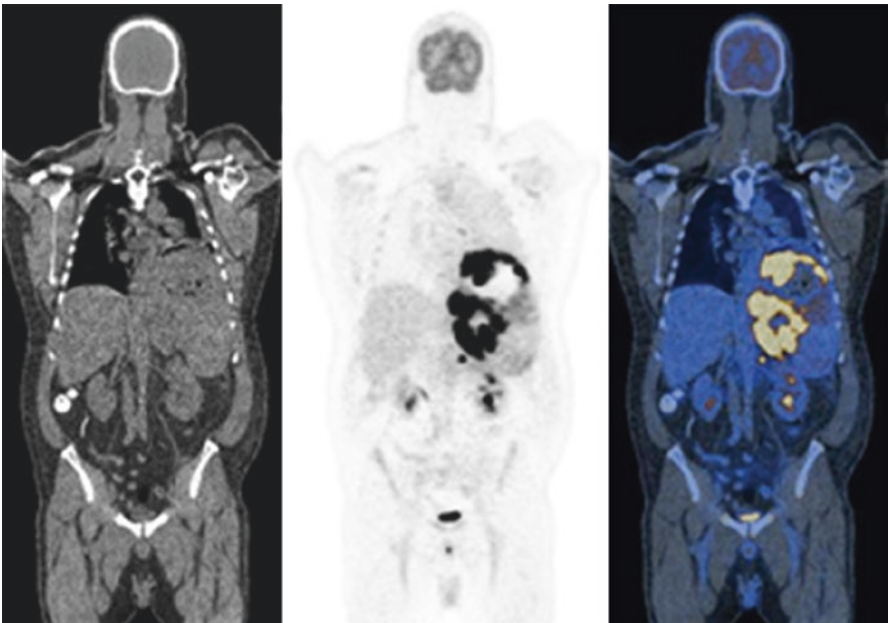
^{18}F -FDG whole body PET/CT acquisition showing CT, PET, fused PET/CT in the coronal plane
